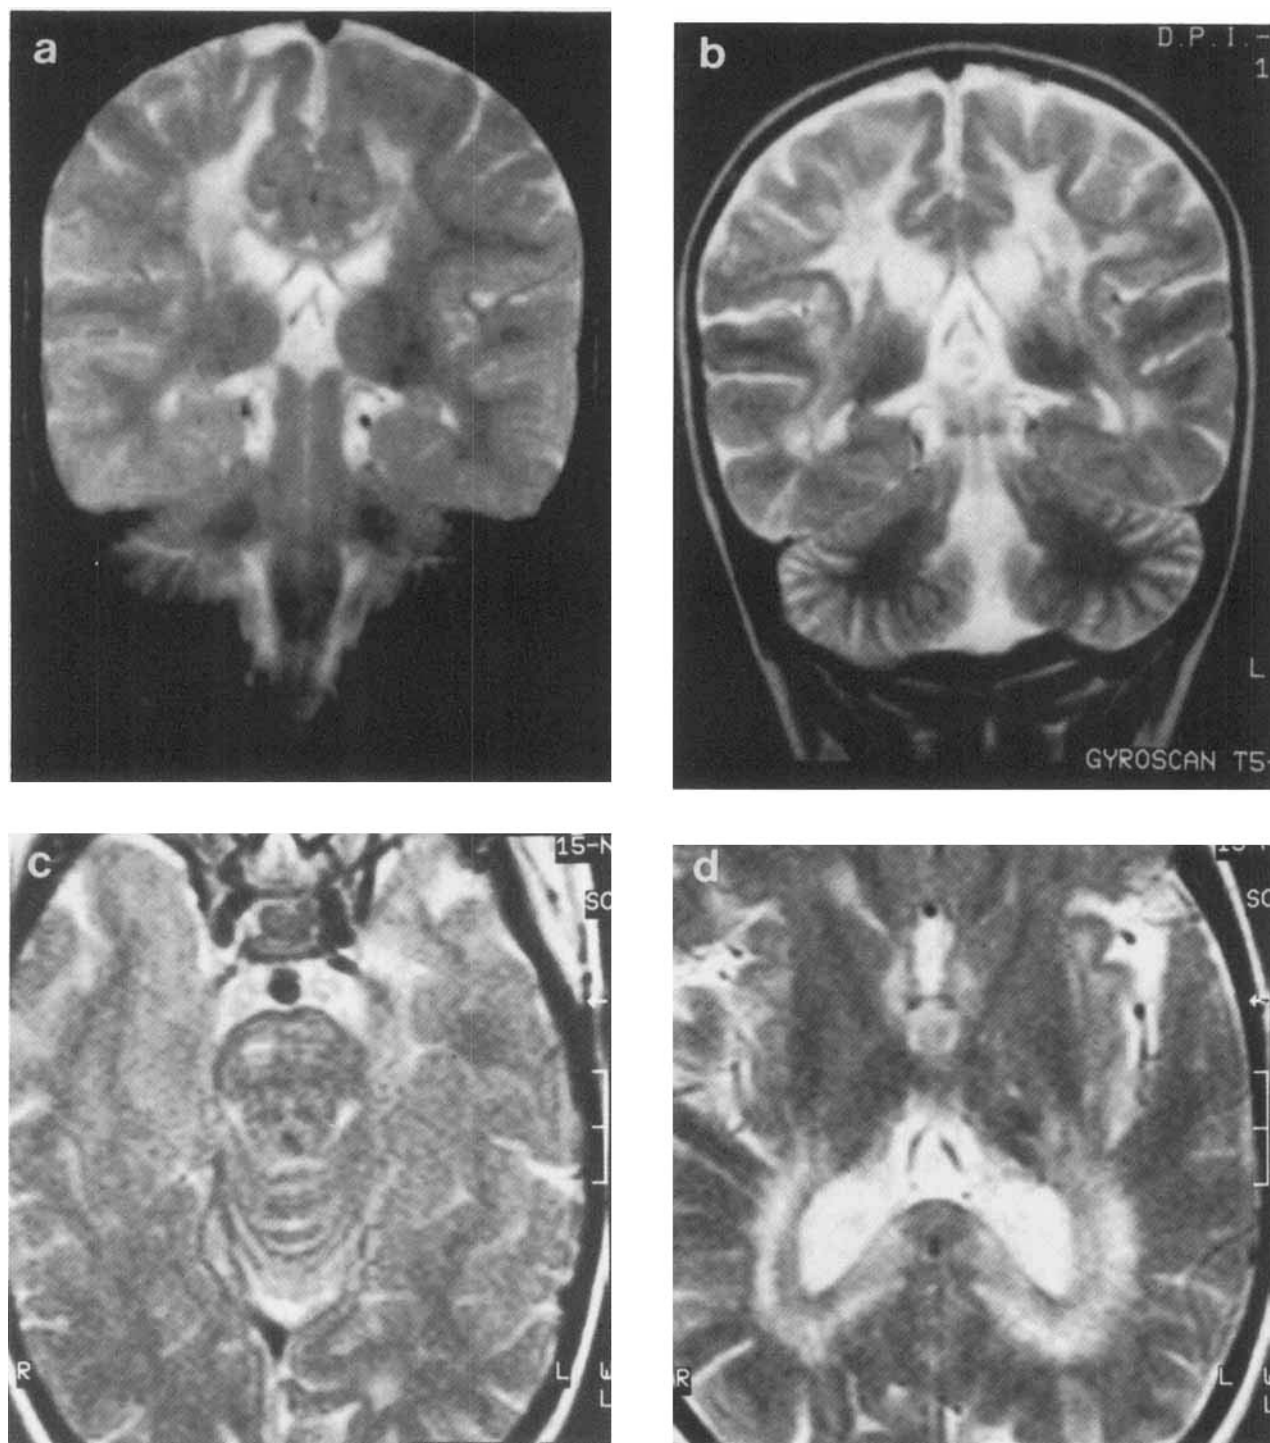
MRI in KD, late-onset form. a: Case 7. Two-year-old child with left hemiplegia. Coronal MRI T2-W (SE, TR, 2,300 msec; TE, 120 msec) at level of aqueduct. Circumscribed and diffuse hyperintensities of supratentorial white matter, mainly centrum ovale. Subcortical U-fibers spared. Signal drop in dentate nucleus. b-d: Same patient 18 months later. She was opisthotonic, with hypertonic flexion of the arms, and extension of the legs and feet. b: Coronal MRI T2-W (SE, TR, 2,872 msec; TE, 120 msec) in similar position as Figure 4a. Progression of white matter hyperintensities with local involvement of U-fibers and ventricular enlargement. Additional cortical atrophy and hypointensity involving both thalami and dentate nuclei. c: Axial MRI T2W (SE, TR, 2,244 msec; TE, 120 msec) at level of upper pons. Circumscribed hyperintensities within pyramidal tract. d: Axial MRI, same parameters as c, at level of basal ganglia. Marked hyperintensity of occipital central white matter, sparing periventricular fibers to some degree. Circumscribed lesions within left internal and external capsules.
